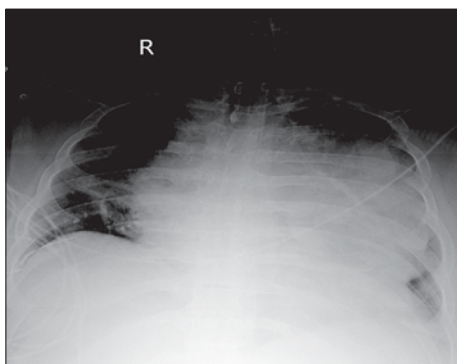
Initial chest X-ray; mediastinal mass with tracheal obliteration
